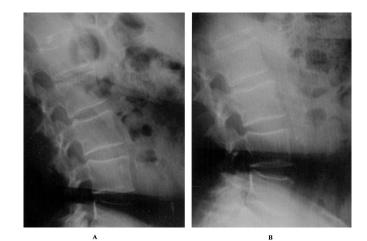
X-rays. Preoperative (*A*) and postoperative (*B*) images of lumbar spine posture. The round mesh improves hyperlordosis and corrects the L2-L3 intervertebral posterior pinching.
